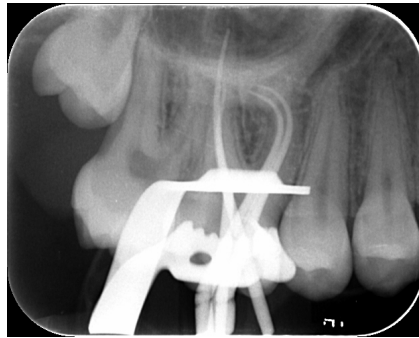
Intra-operative x-ray with fitted master points.
